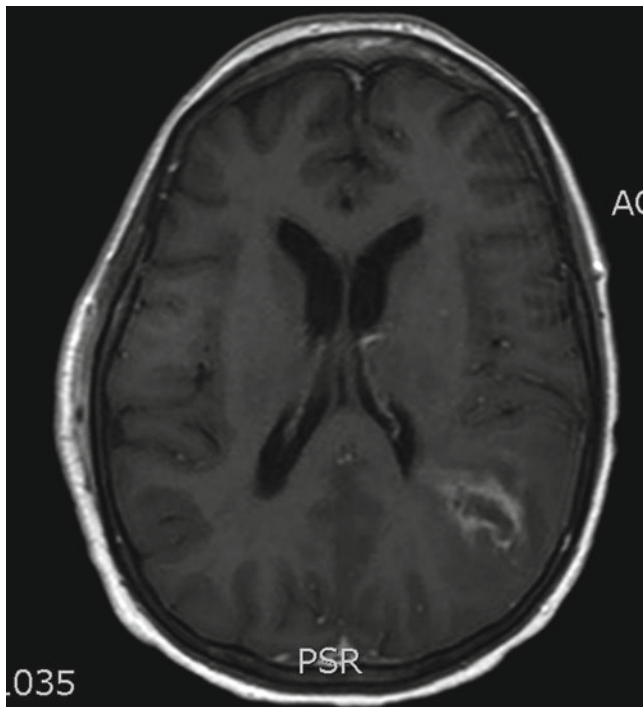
MRI demonstrating ill-defined enhancing focus with surrounding vasogenic-type edema in the juxtacortical left parietal lobe.
